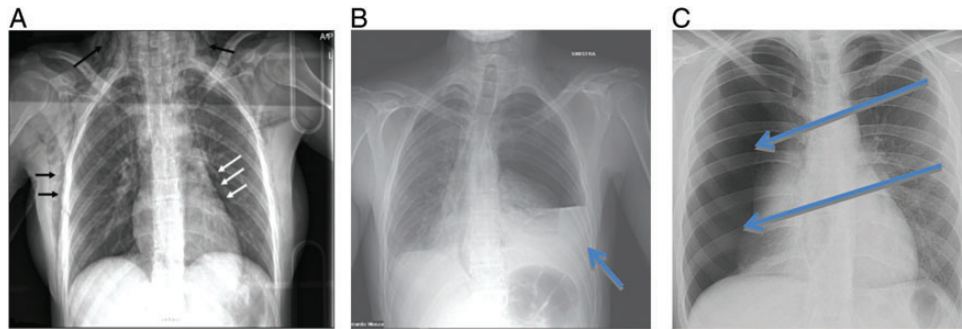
Radiographic presentations of oesophageal injury shown on PA chest radiographs: (A) subcutaneous emphysema (black arrows) and pneumomediastinum (white arrows); (B) left-sided pleural effusion (arrows); and (C) right-sided pneumothorax (arrows).
